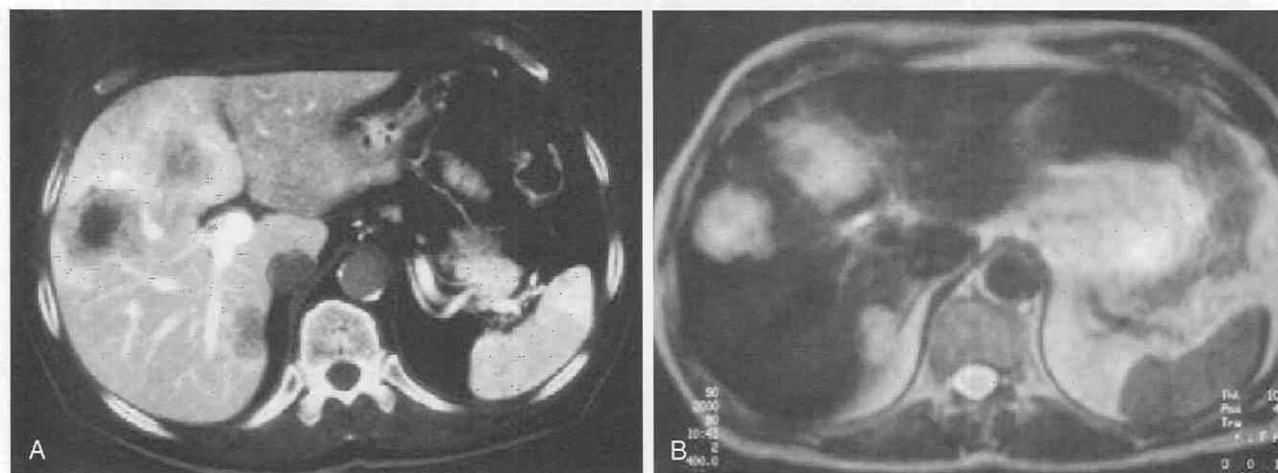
Liver metastases. *A*, Contrast-enhanced CT scan demonstrates multiple hepatic lesions, with abnormal enhancement involving most of the anterior segment. *B*, T2-weighted image after superparamagnetic iron oxide (SPIO) administration more clearly identifies the margins of the lesions.
